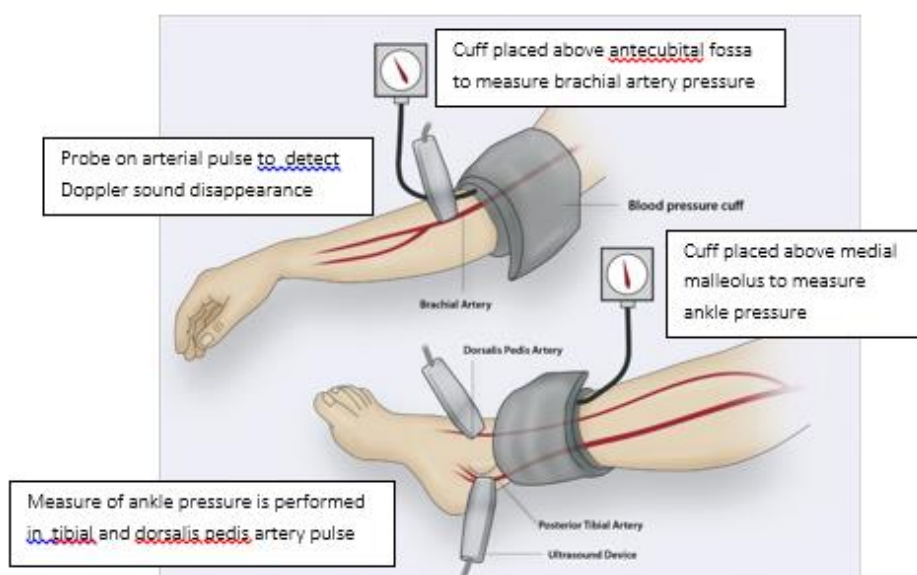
Measurement of the brachial systolic pressure and ankle systolic pressure with a sphygmomanometer and a Doppler ultrasound device.
